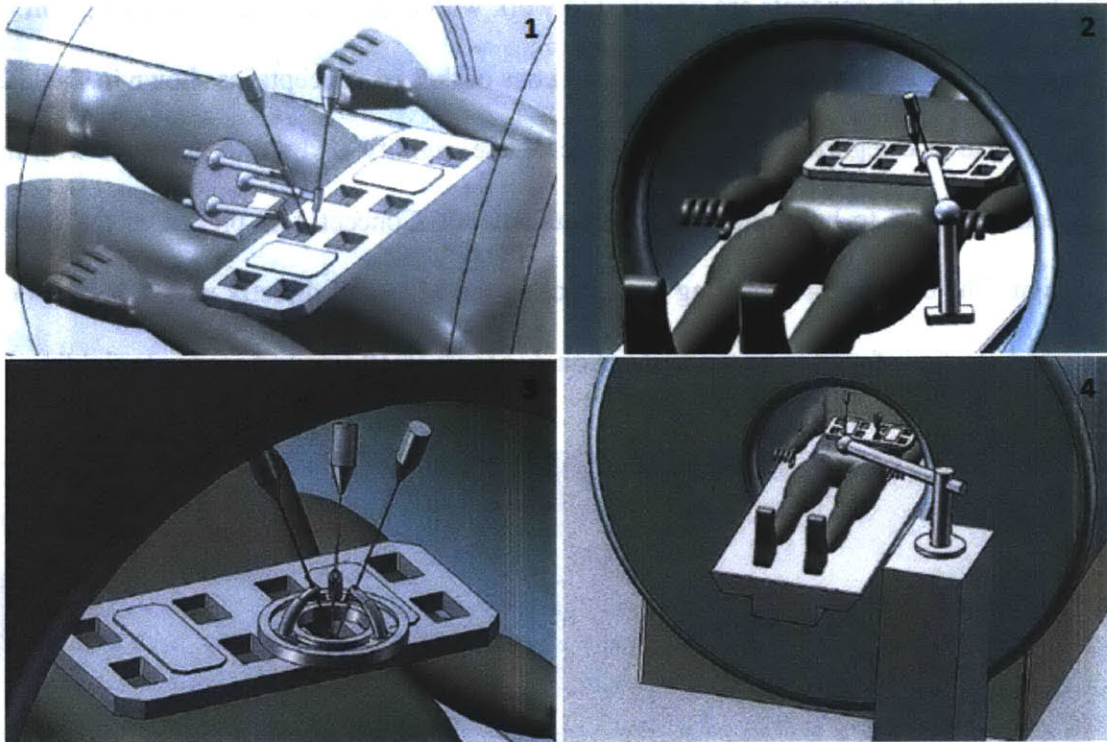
Initial strategies of device mounting module. (1) Mounting the device to the patient. (2) Mounting the device to the MRI bed. (3) Mounting the device to a large rectangular MRI imaging coil. (4) Mounting the device to a frame outside of the MRI [16].
